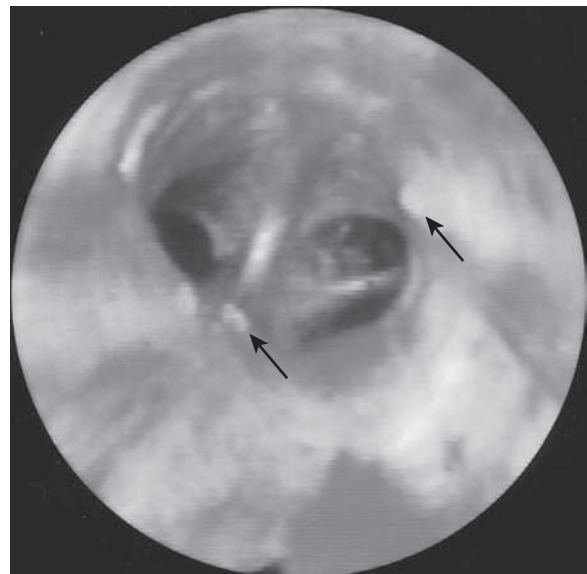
Fiberoptic bronchoscopy, demonstrating pieces of sand (arrows), significant airway erythema, and inflammation following drowning and sand aspiration. (From Dunagan DP, Cox JE, Chang MC, et al: Sand aspiration with near-drowning: Radiographic and bronchoscopic findings, Am J Respir Crit Care Med 156:292, 1997.)
